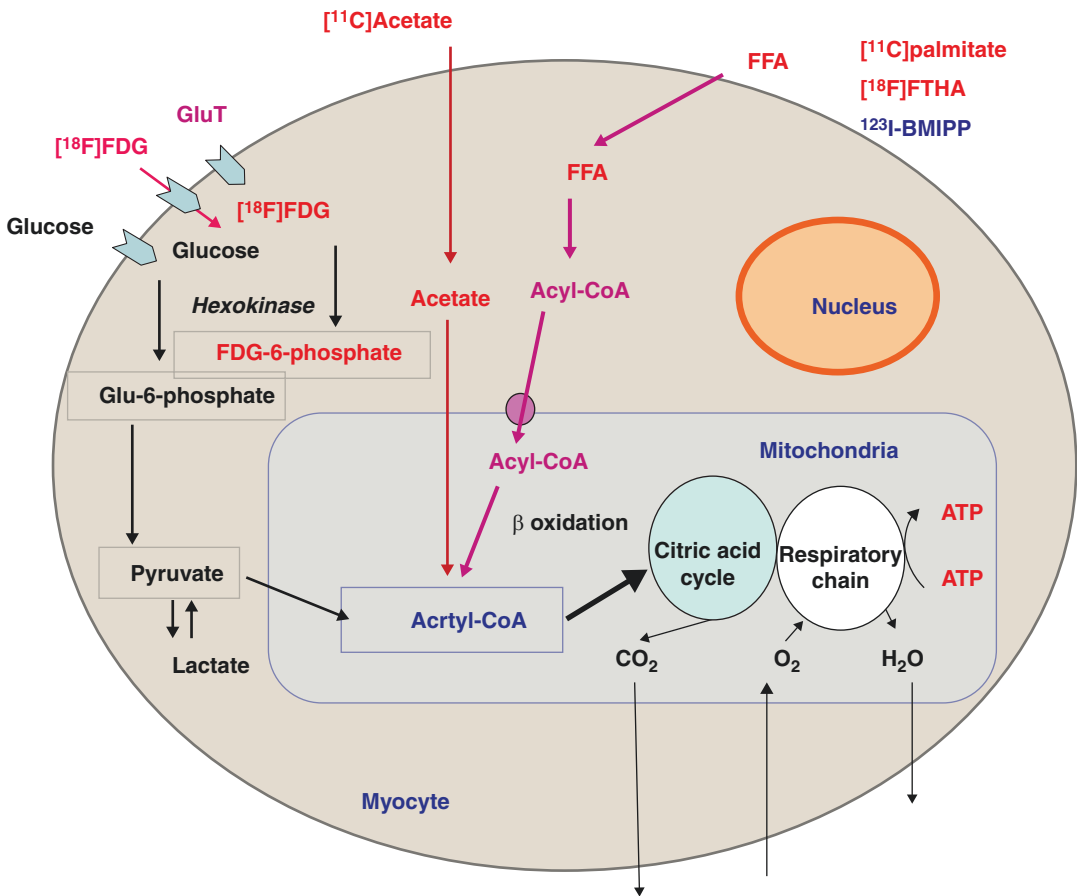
PET and SPECT radiotracers to image myocardial substrate utilization and metabolism
